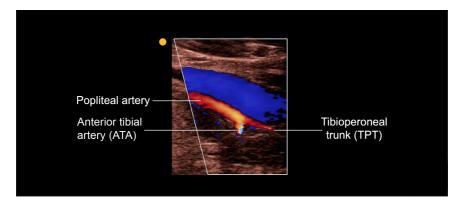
The popliteal vein is located above the arteries on color flow duplex ultrasound when the popliteal artery bifurcates into the anterior tibial artery (ATA) and tibioperoneal trunk (TPT).
